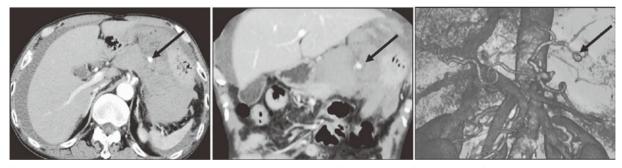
Contrast-enhanced computed tomography demonstrated an enhancing small mass with a hematoma in the lesser omentum. Three-dimensional computed tomography revealed the enhanced mass to be a left gastric artery aneurysm.
